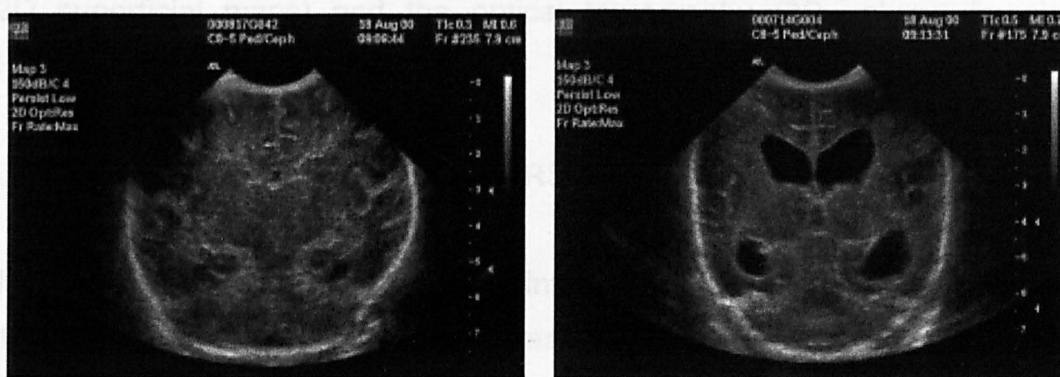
LEFT: Slice selection in coronal view showing normal cranial ultrasound, with the skull appearing as dense white echoes (Halliday et al, 1998) (p373). RIGHT: Fluid filled cerebral cavities on both sides as a result of an intraventricular haemorrhage, (Suetens, 2001) (p106).
